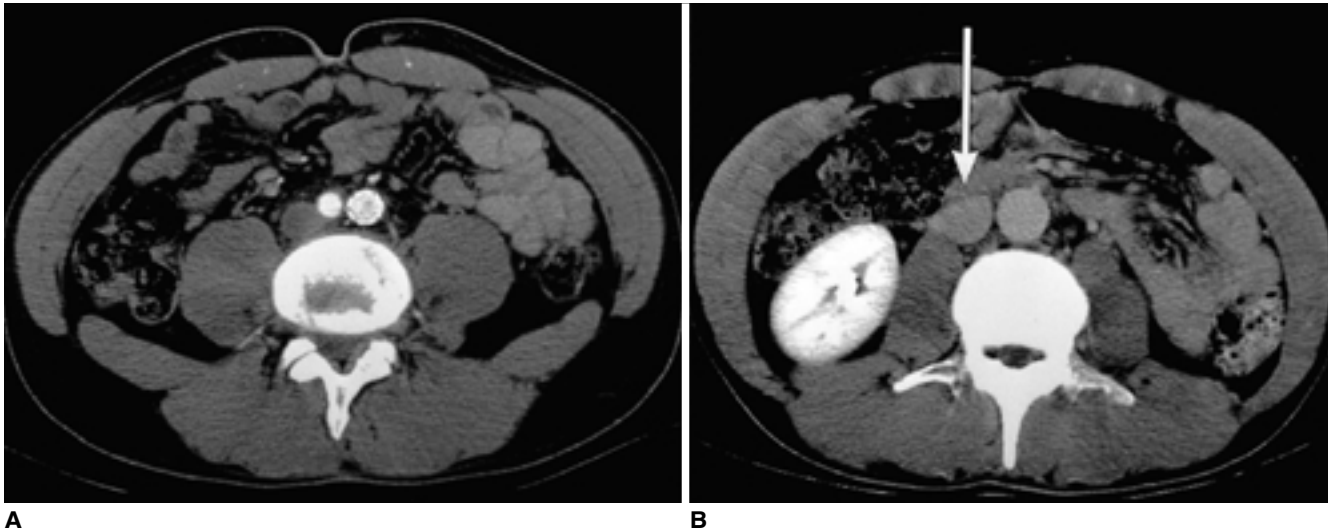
Follow-up CT scan after 2 months shows (A) patent stent-graft and (B) restoration of IVC diameter to normal level(arrow).
